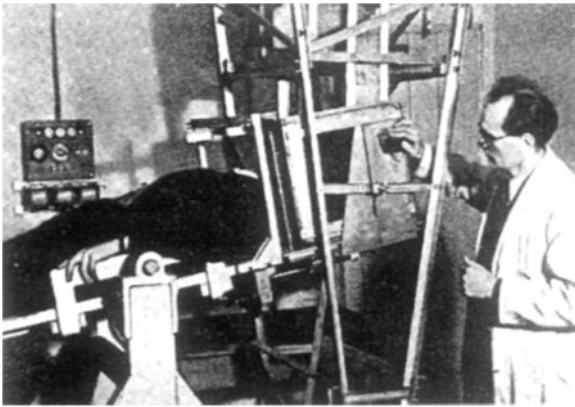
Karl Dussik and his ultrasound apparatus in 1946 (Christian *et al.* 2014)
